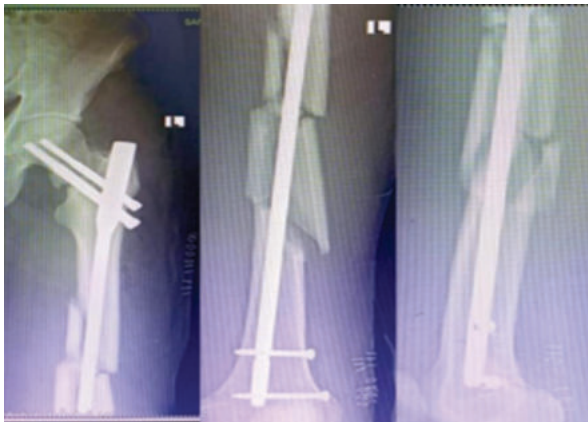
immediate Post Operative Xrays
